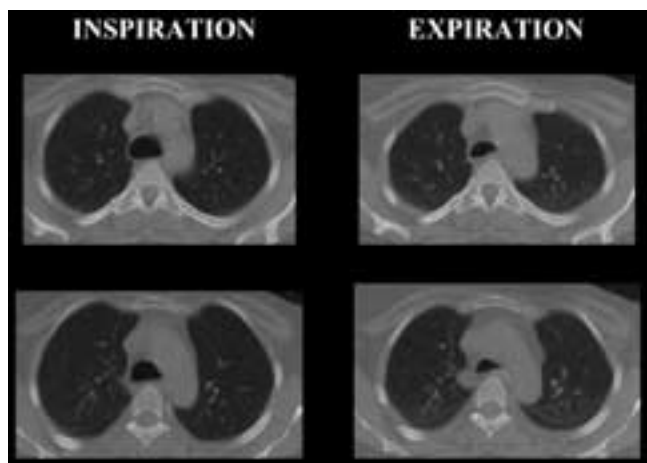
Tracheomalacia. A 62-year-old female with an increasingly loud, uncontrollable cough. Inspiratory and expiratory axial CT images of the upper thorax demonstrate a 44% reduction in the anteroposterior tracheal diameter on expiration. Both flexible and rigid bronchoscopy revealed a flattened, lax trachea with a redundant membranous wall.
